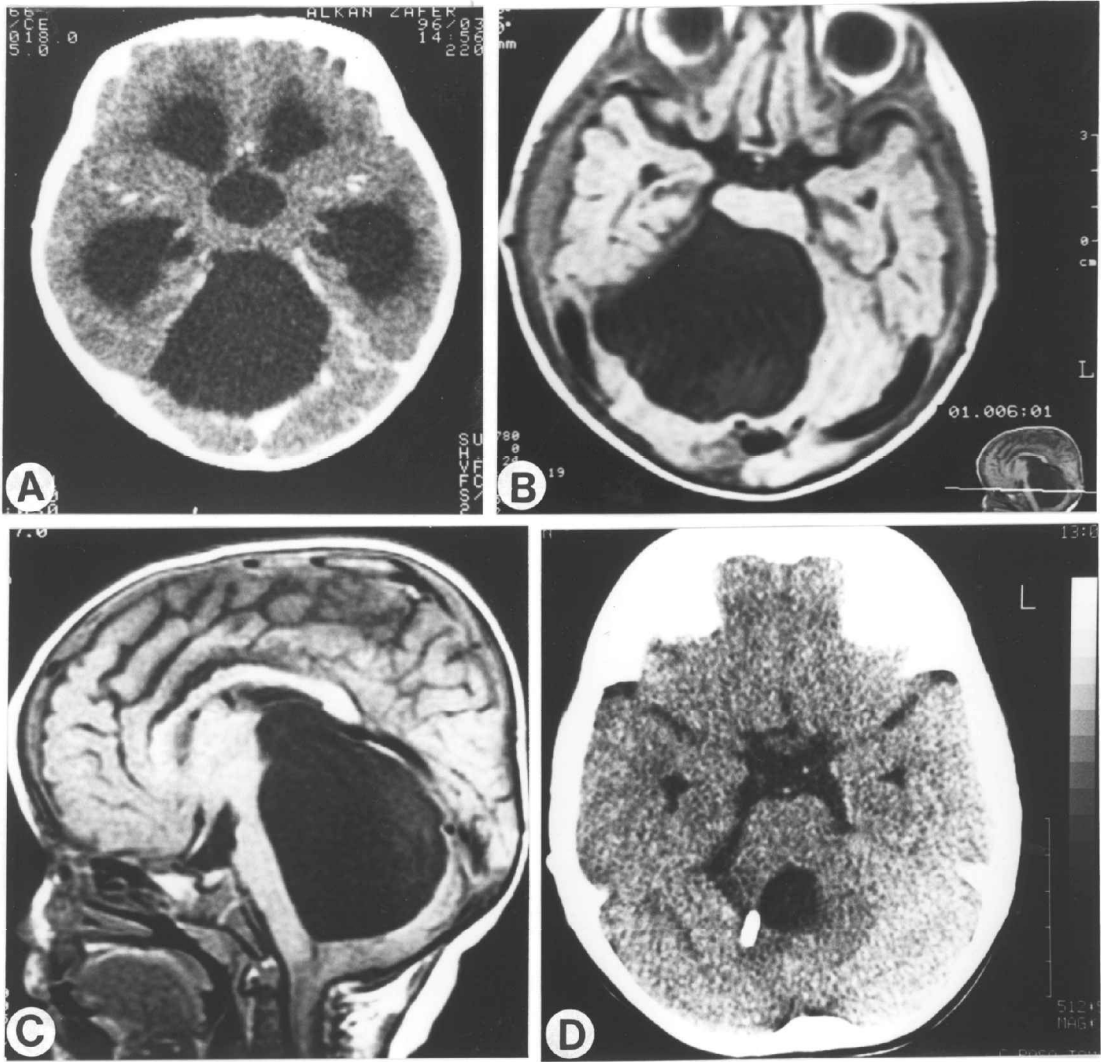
Case 10. (A) Axial CT scan shows massive dilation of the third and lateral ventricles. The arachnoid cyst lies at the tentorial incisura. (B) Three months after insertion of a VP shunt, T1-weighted axial MRI scan shows bilateral subdural haematomas, and an enlarged arachnoid cyst at the tentorial incisura. (C) T1-weighted mid-sagittal MRI scan shows the supracerebellar arachnoid cyst filling the posterior fossa. Note that despite the size of the cyst, the posterior fossa is not enlarged and the torcula is normally positioned. (D) CT scan 1 year after CP shunting, demonstrates the disappearance of the bilateral subdural hematomas and arachnoid cyst.
